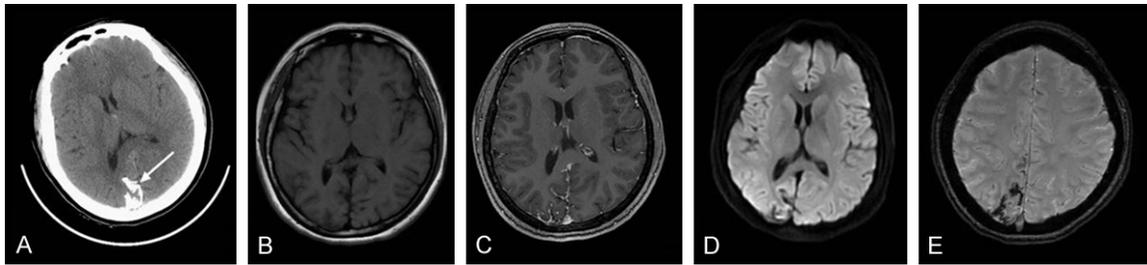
Cerebral CT and MRI findings (lesions in the cortical and subcortical layers of the right occipitoparietal region, white arrow). A: CT showing linear calcifications. B: MRI-T1 weighted axial image showing a low signal. C: MRI-enhanced T1 axial image showing slight enhancement. D: Diffusion-weighted MRI showing a low signal. E: Susceptibility weighted image showing a low signal.
